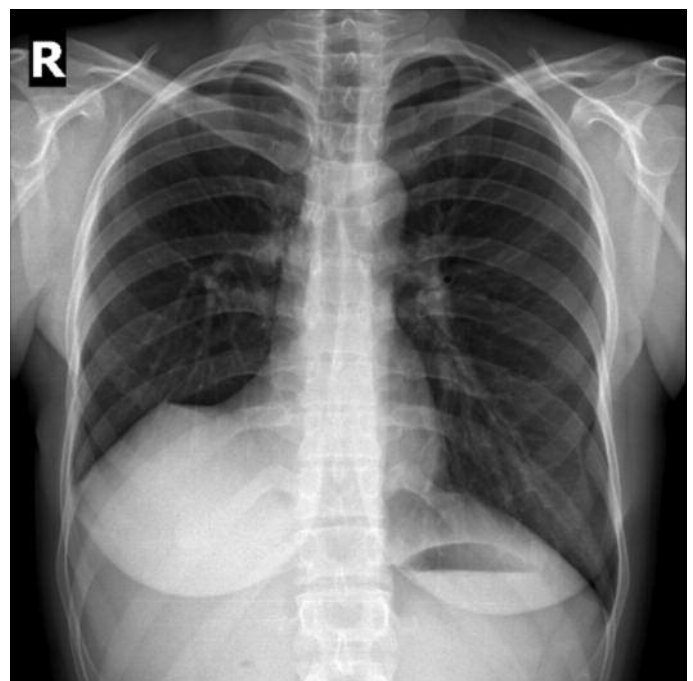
Chest X-ray after the removing Heimlich valve. Lung is fully expanded in chest X-ray.
